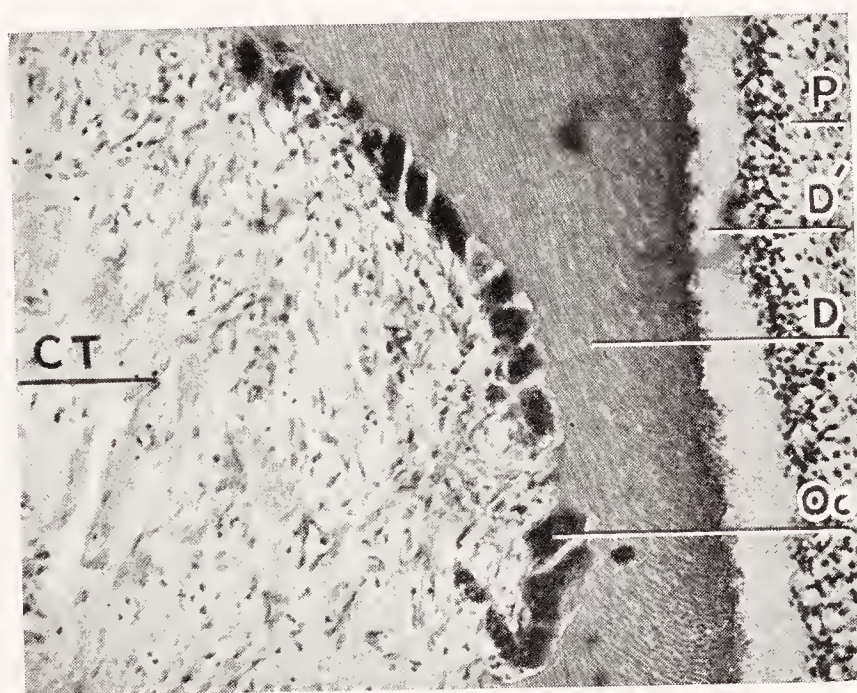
Higher magnification of the dentin resorption in Figure 255. The entire dentin surface is densely beset with polynuclear osteoclasts (giant cells). *P*, pulp; *D'*, predentin; *D*, dentin; *Oc*, osteoclasts lying in Howship's lacunæ in the dentin; *CT*, connective tissue. (Mueller, Jour. Am. Dent. Assn.)
